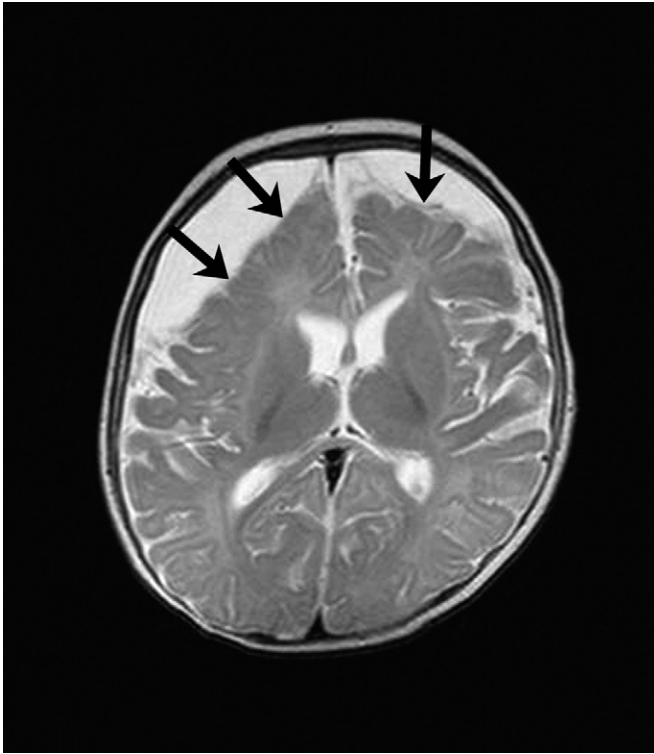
Chronic subdural effusions following meningitis. Axial T2-weighted MRI shows mass effect with sulcal compression associated with bifrontal subdural collections (*arrows*). Note that these subdural collections can be differentiated from enlarged subarachnoid spaces because the latter would have bridging vessels crossing the cerebrospinal fluid in the subarachnoid spaces.
